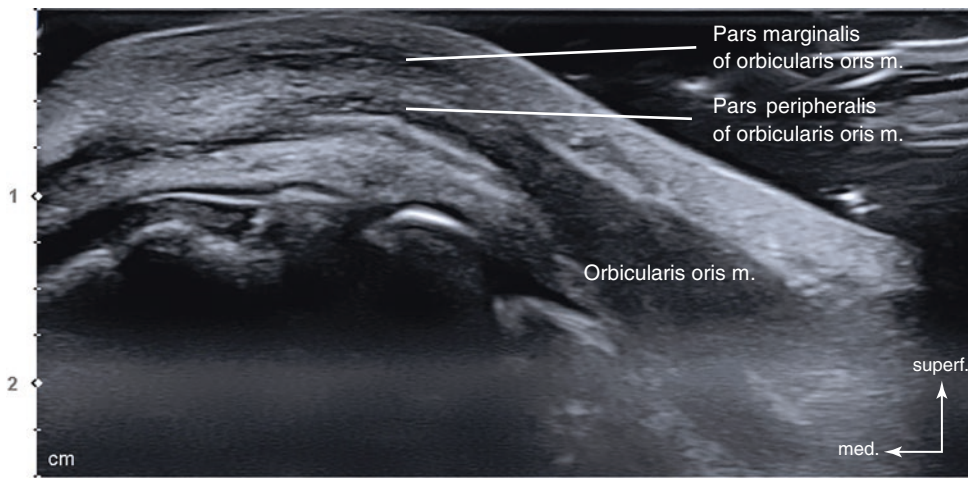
Ultrasonography of the oblique line between Ls2 and Ls3 (Ls2–Ls3). B mode (oblique view, 15 MHz by linear transducer). (Published with kind permission of © Hee-Jin Kim 2020. All Rights Reserved)
